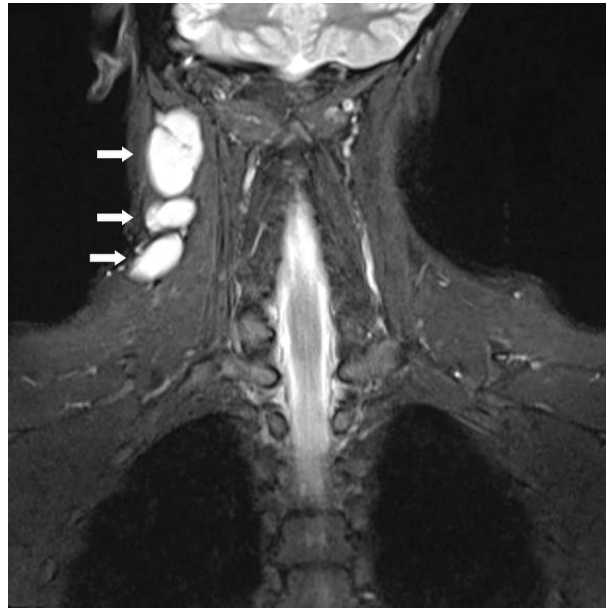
Multiple enlarged lymph nodes that appear strongly hyperintense on T2-weighted coronal image on the right cervical region (horizontal arrows)
